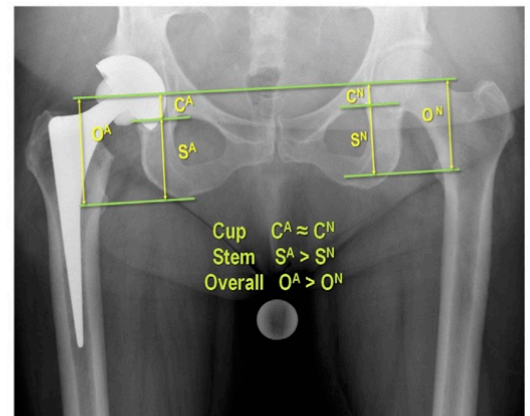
The Leeds method for measuring LLI on a radiograph. The reference line bisects the centres of femoral rotation. Two further parallel lines per hip are then drawn, the first at the level of the acetabular teardrop and the second at the level of the midpoint of the lesser trochanter. This produces three measurements per hip, C equating to any LLI due to the cup position, S any LLI due to the stem and overall measurement O. In this case the C measurements are similar, S is greater on the arthroplasty side and the overall measurement, O, is greater. Therefore the lengthening in this arthroplasty is predominantly due to the stem.
